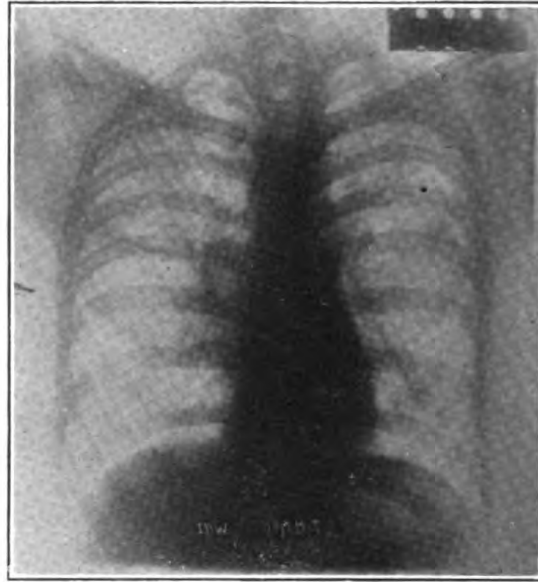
The X-ray shows a moderate degree of infiltration of the right upper lobe and to a lesser degree of the left upper lobe. The lung roots, right side, are very prominent and thickened and the lung markings run from it well into the apices and toward the periphery. In the region of the 4th right rib there is an area of calcification about 1 cm. in diameter. The heart is of the vertical type and the lung interspaces are widened. Diagnosis: Pulmonary tuberculosis. Asthma.
